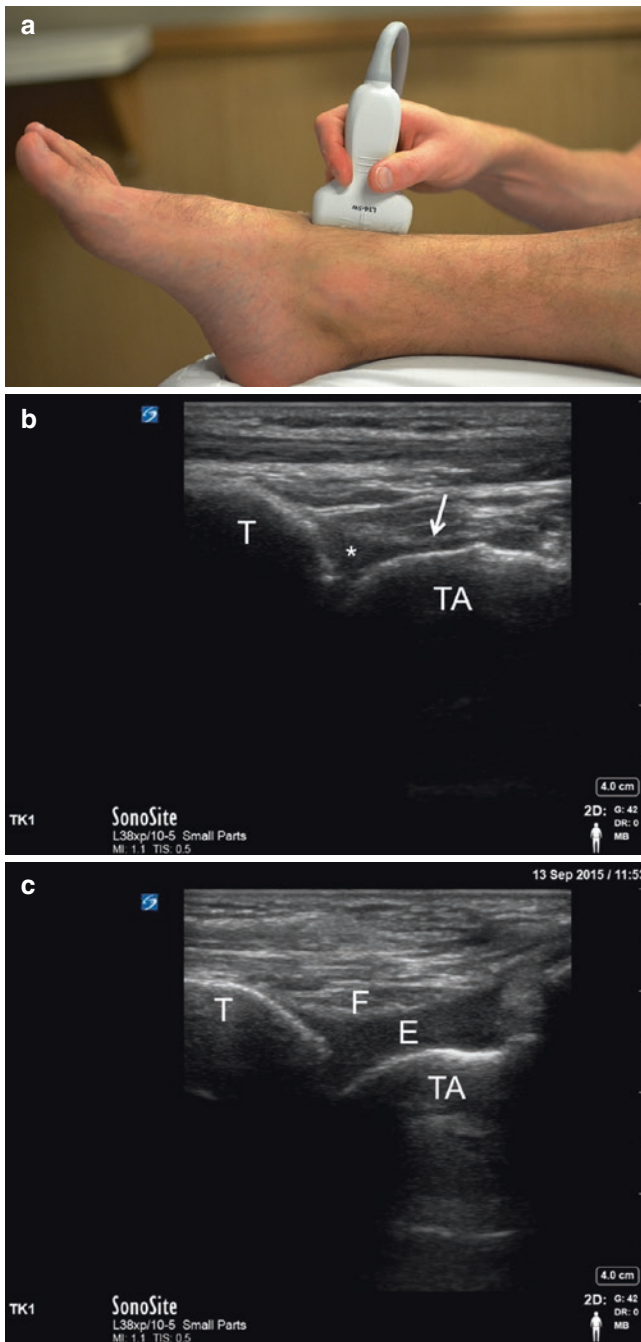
(a) Ultrasound is highly sensitive for diagnosing ankle joint effusions, which are predominately visualized in the anterior recess. A linear probe should be used and placed longitudinally with the probe marker pointed cranially over the distal end of the tibia's articulation with the talar dome, while the patient's foot is in slight plantar flexion. (b) The talar dome (TA) articulates with the tibia (T) and is covered with hyaline cartilage (*arrow*), which should not be mistaken for an effusion. A normal amount of fluid can be seen within the joint space (*asterisk*); this should measure less than 1.8 mm in the anterior-posterior diameter. (c) More than 1.8 mm of anechoic fluid in the anterior-posterior diameter indicates joint effusion (E). Once the tibia (T) and talar dome (TA) are visualized, scanning medial and lateral will allow visualization of the entire joint space. Joint effusion in the anterior recess is also distinguished by displacement of the anterior fat pad (F), which becomes compressed by the anechoic fluid
